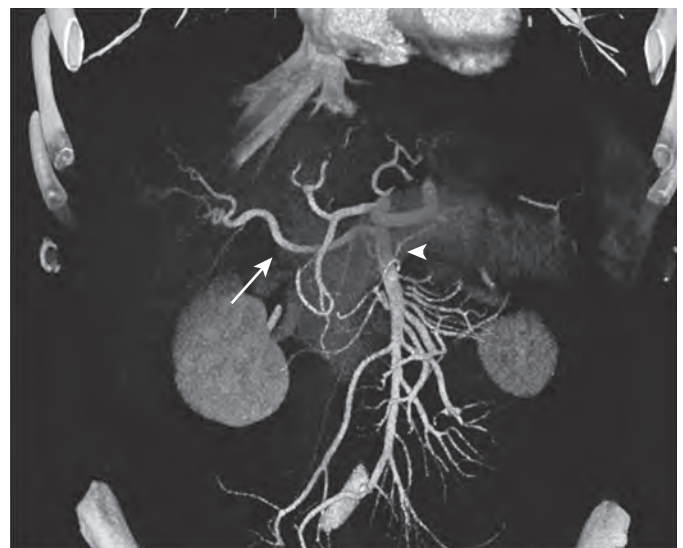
CT angiogram for staging of pancreatic head carcinoma. Shown is the replaced right hepatic artery (arrow) arising from the superior mesenteric artery (arrowhead).
